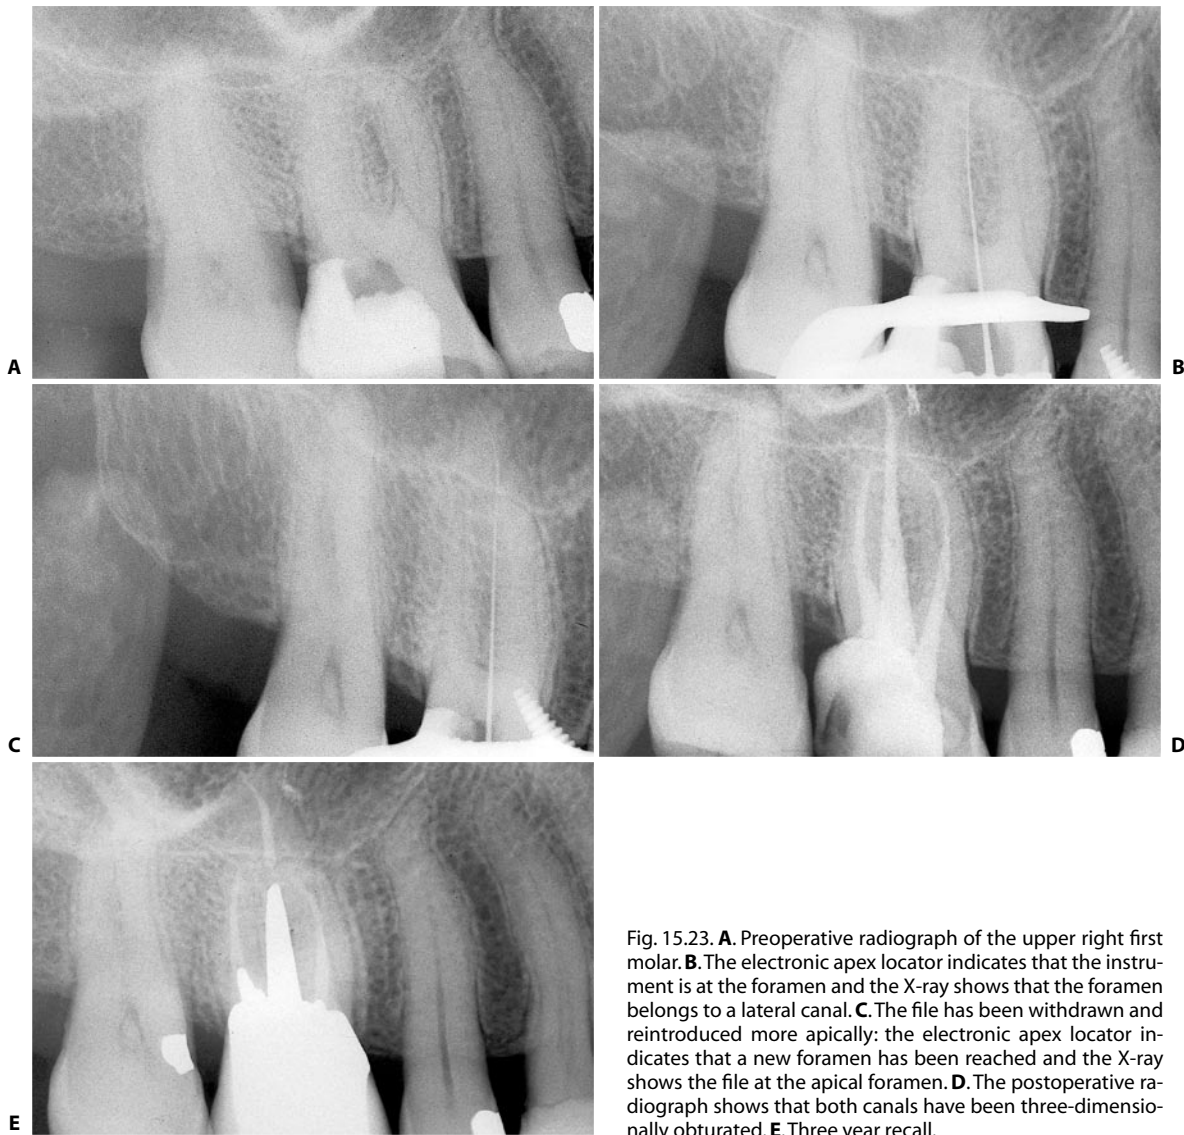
A. Preoperative radiograph of the upper right first molar. B. The electronic apex locator indicates that the instrument is at the foramen and the X-ray shows that the foramen belongs to a lateral canal. C. The file has been withdrawn and reintroduced more apically: the electronic apex locator indicates that a new foramen has been reached and the X-ray shows the file at the apical foramen. D. The postoperative radiograph shows that both canals have been three-dimensionally obturated. E. Three year recall.
